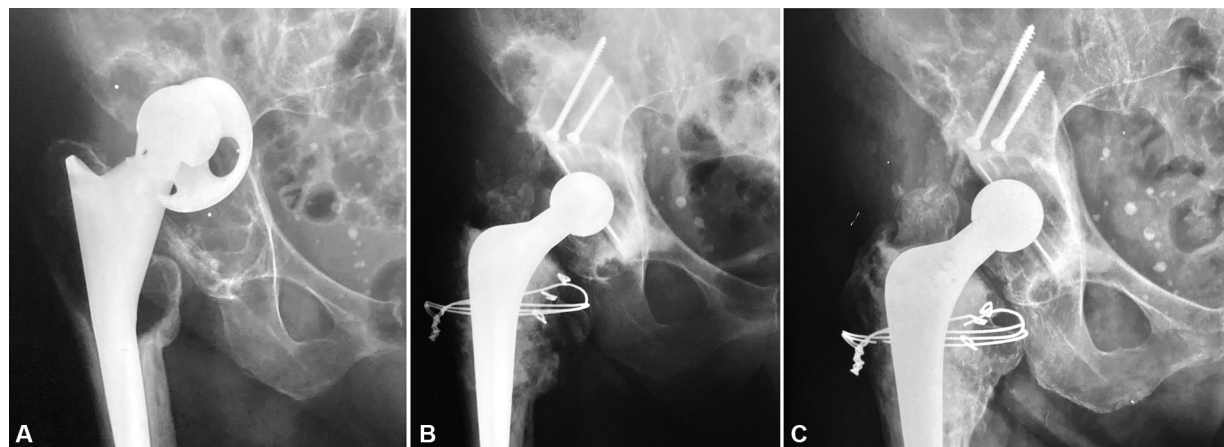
Radiographs of a 73-year-old female patient who had her right hip operated. A) preoperative radiography showing noncemented total hip arthroplasty with combined defect (D'Antonio); Paprosky 3B, measuring 82 mm; B) immediate postoperative radiography presenting acetabular reconstruction with structural graft and cemented acetabular component; C) postoperative radiography at 10 years and 6 months after acetabular reconstruction without signs of release.
